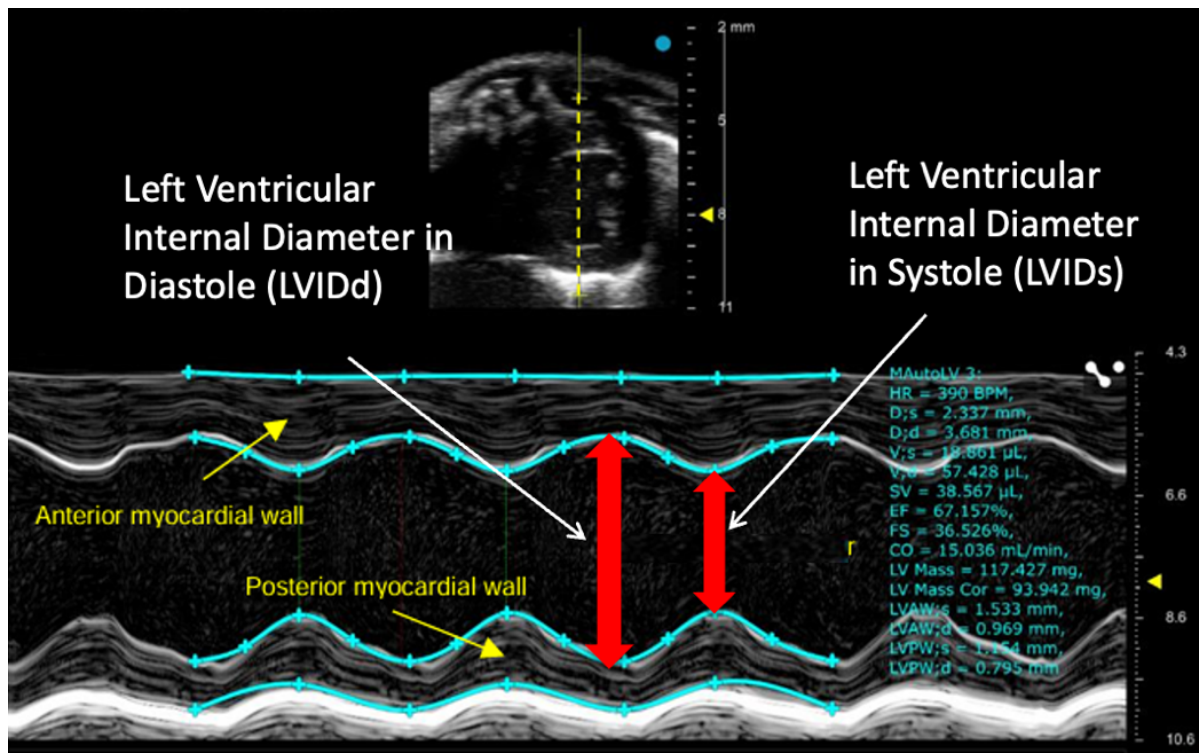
M-mode echocardiography snapshot indicating FS% measurements.^[1]
